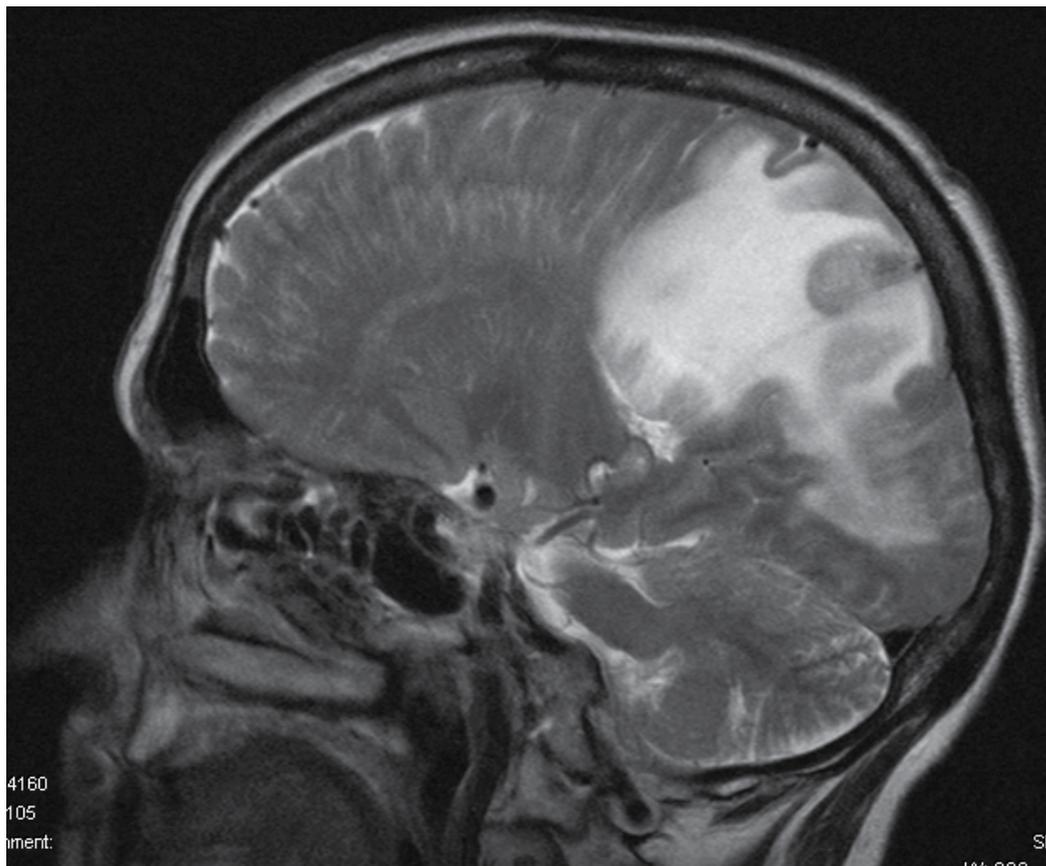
Sagittal MRI section, hyperintense lesion on T2 - weighted image.
